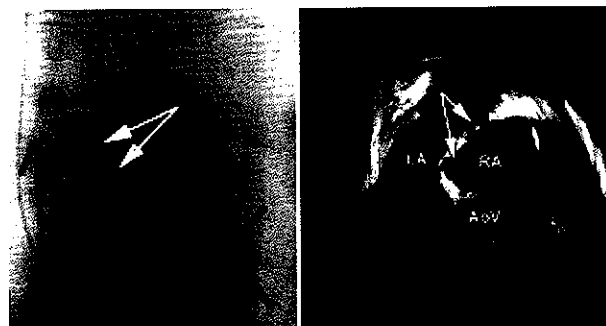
(A, left) Anteroposterior fluoroscopy view of the dilator sheath (double arrows) and the intracardiac ultrasound catheter at the time of the picture in panel B. (B, right) View of interatrial septum and fossa ovalis with intracardiac echocardiography. The double arrow is pointing to the dilator sheath and the intracardiac echocardiography probe. The dilator sheath is moving in the direction of the fossa ovalis from the contralateral side of the aortic valve. AoV, aortic valve; LA, left atrium; RA, right atrium.
